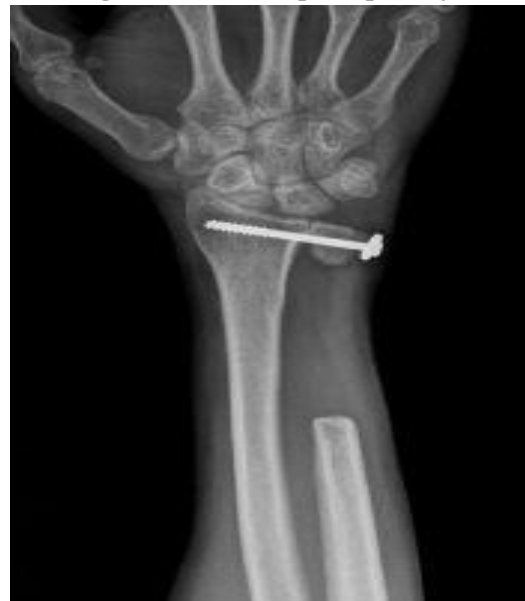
6 months post op X-ray.
